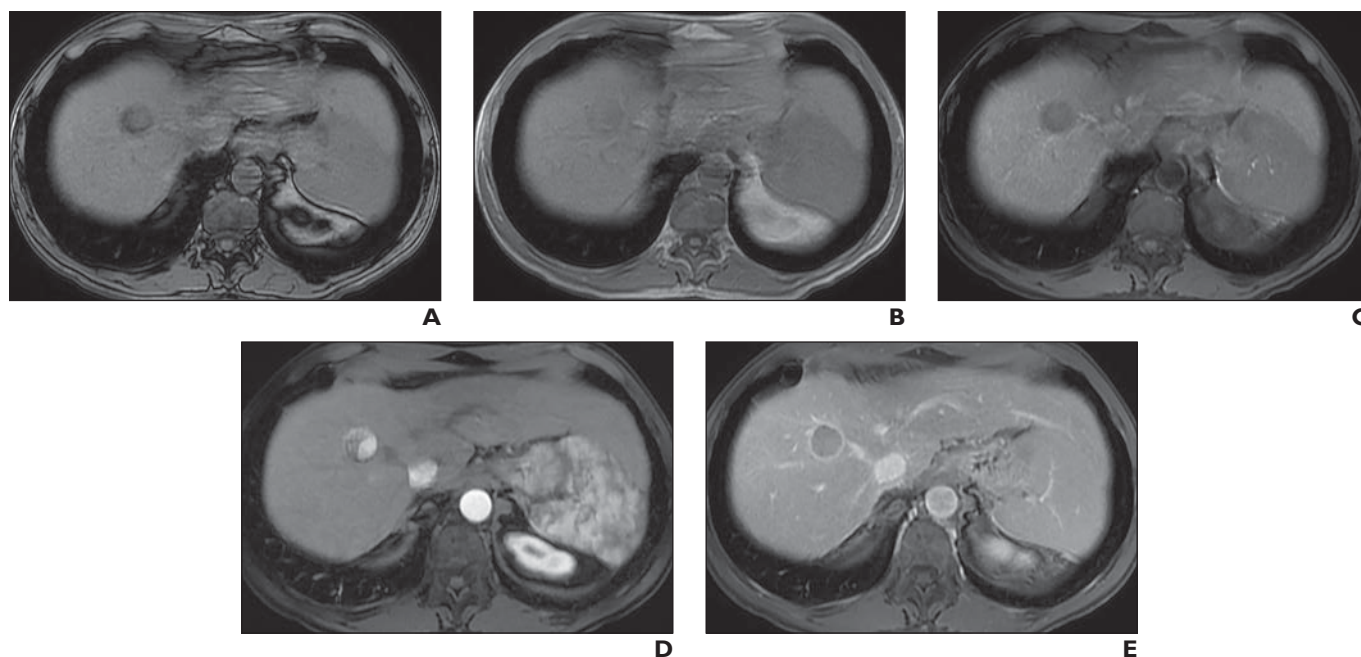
63-year-old man with hepatitis C and hepatocellular carcinoma. Example of intralesional steatosis. Lesion exhibits loss of signal intensity on out-of-phase T1-weighted MR images compared with in-phase images. Lesion has increased signal intensity on T2-weighted single-shot fast spin-echo and T2-weighted fat-suppressed images. Lesion measures 2.1 cm and exhibits arterial phase enhancement compared with unenhanced images and washout on later phase images with capsule present; therefore it is assigned to LI-RADS category 5.
